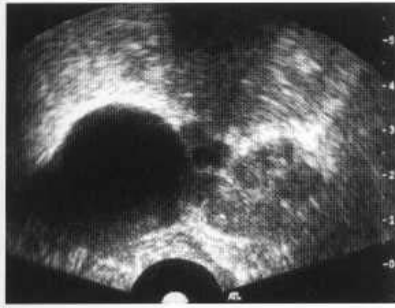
Transverse image from a transrectal ultrasound examination showing a normal left seminal vesicle and a large right seminal vesicle cyst.
